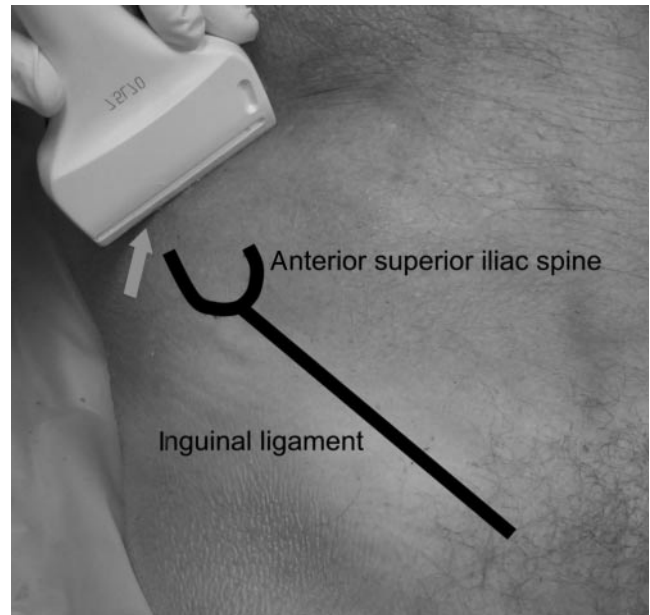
Transducer position for the ultrasound-guided II and IH nerve blocks. The arrow indicates the contact point of the transducer with the iliac crest.
